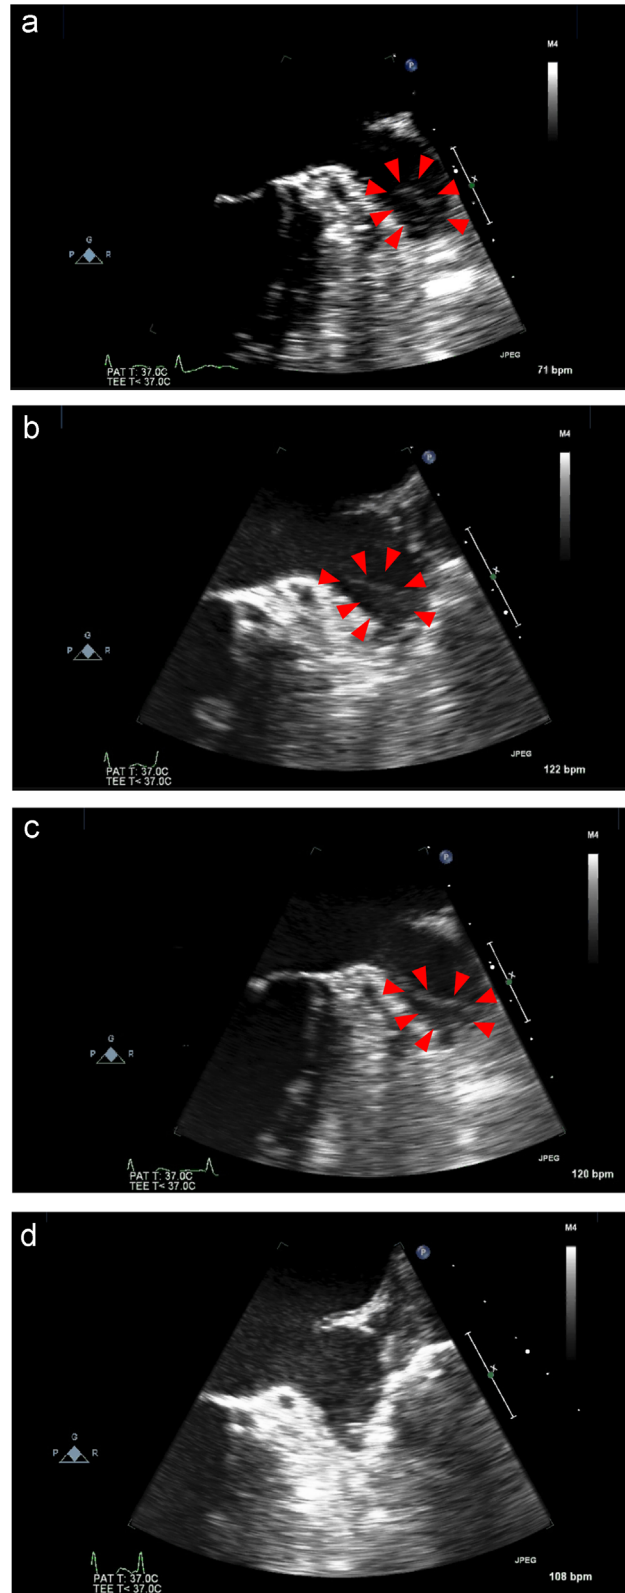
Panel A: transesophageal echo shows mobile thrombus in the left atrial appendage (LAA). Panel B: no change of LAA thrombus after three months of anticoagulation with warfarin. Panel C: no change of LAA thrombus with dabigatran. Panel D: resolution of LAA thrombus after anticoagulation with apixaban.
